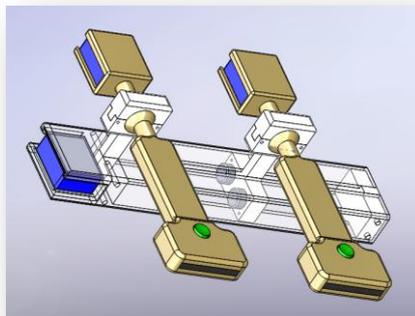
The ultrasound device for the estimation of the pelvic tilt.
